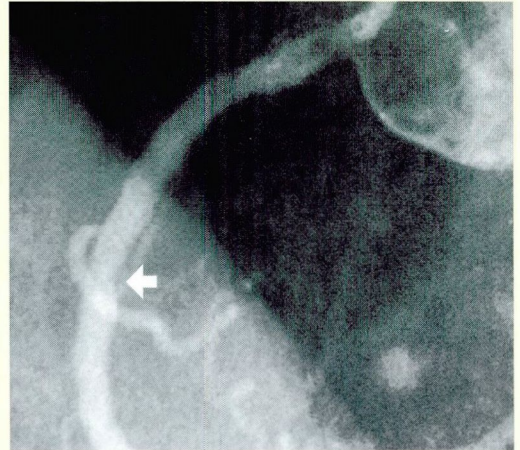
Left, preangioplasty angiogram (top) and intravascular ultrasonogram (bottom) of the right coronary artery show a concentric, fibrotic lesion and a lumen cross-section area of less than 0.25 mm². Top right, postangioplasty angiography indicates a 25-fold increase in cross-section area to 6.25 mm². Bottom right, postangioplasty ultrasonogram shows that the actual increase in lumen cross-section area was only about twofold. During angiography, the contrast medium infiltrated the scimitar-shaped tear in the plaque, which the angiogram misidentified as part of the lumen.
